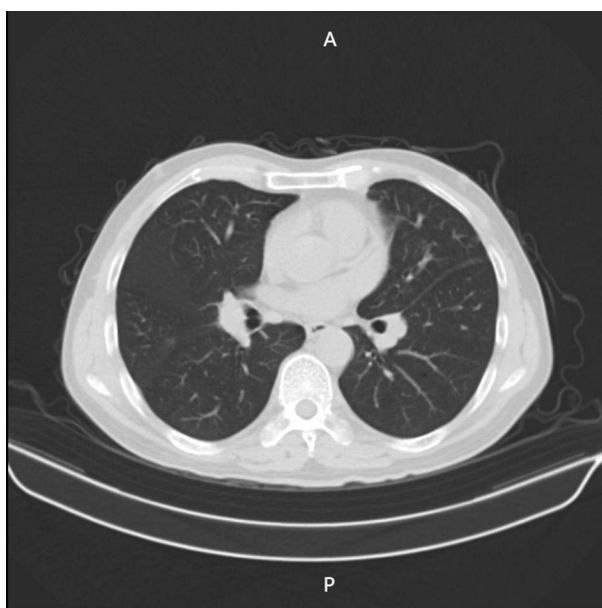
Chest computed tomography scans revealed linear, patchy, and nodular high-density lesions in the lungs.
